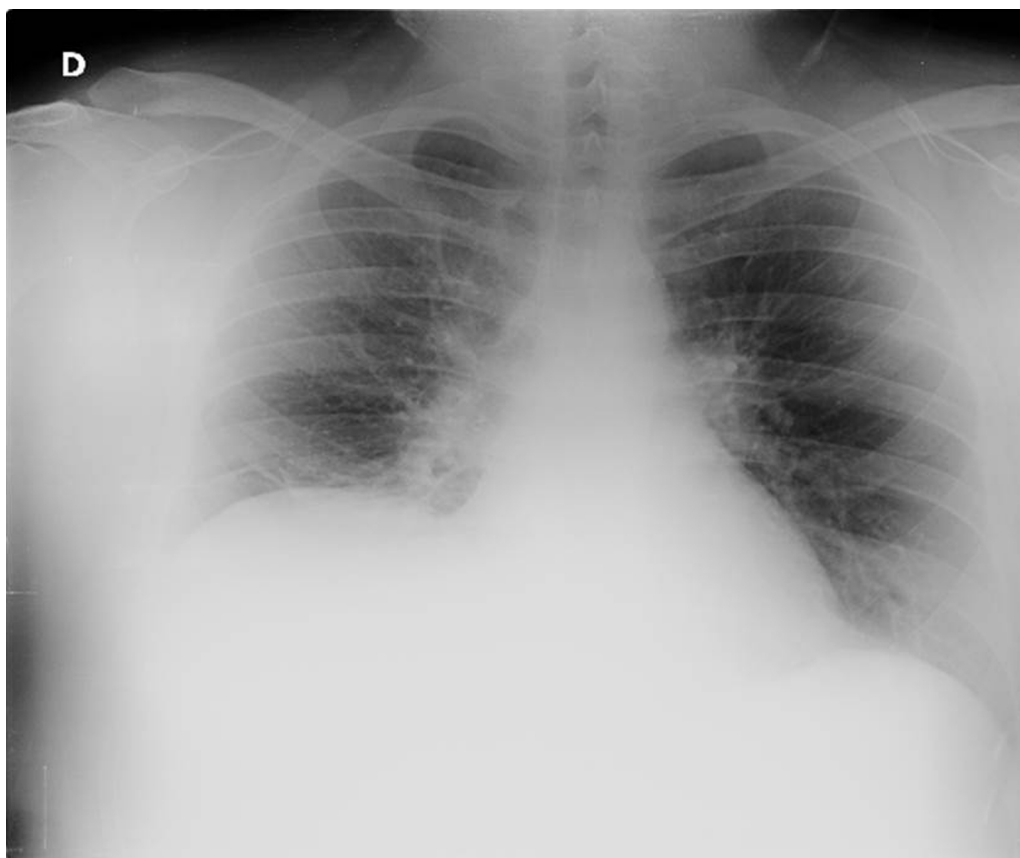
Chest radiograph showing a lift of right hemidiaphragm with ipsilateral scanty pleural effusion.
